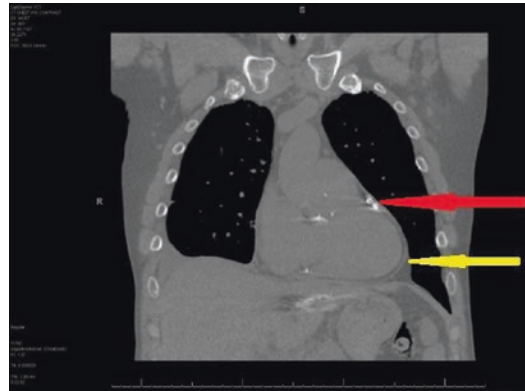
CT of pericardium. Red arrow shows calcification of the pericardium. Yellow arrow shows marked thickening of the pericardium. Both findings suggest constrictive pericardial disease. Note the absence of a significant effusion
